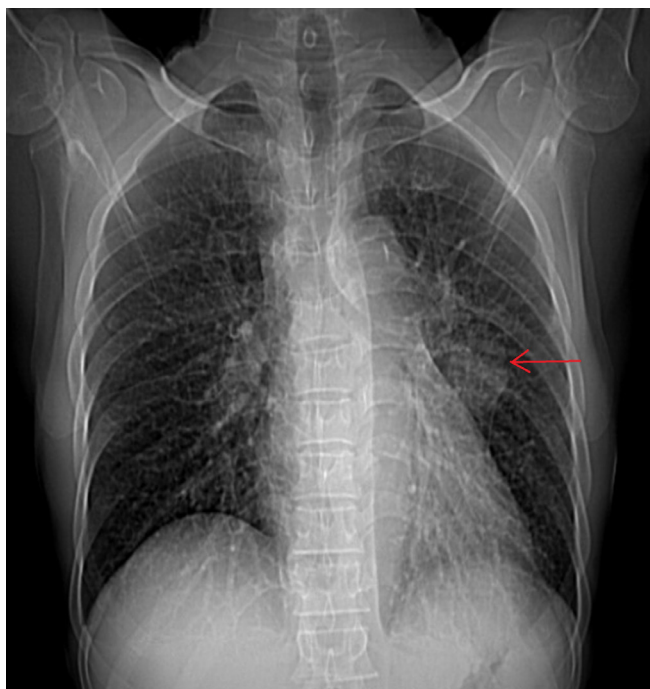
Chest X-ray showing non-homogeneous opacity in the left hilar region. The red arrow points towards the non-homogeneous opacity in the left hilar region.
